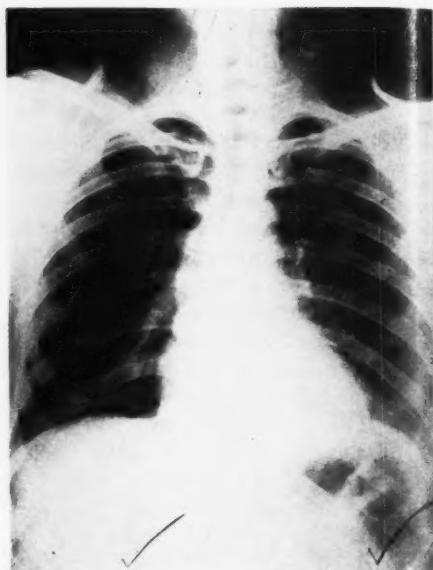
Postoperative roentgenogram of chest (anteroposterior view) made on May 3, 1948, shows normal cardiovascular silhouette. The cyst, previously apparent, is no longer visible.
